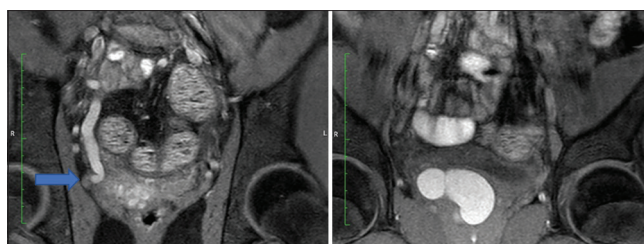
T1-weighted coronal image showing dilated right ureter with ectopic insertion into the right seminal vesicle duct/ejaculatory duct
